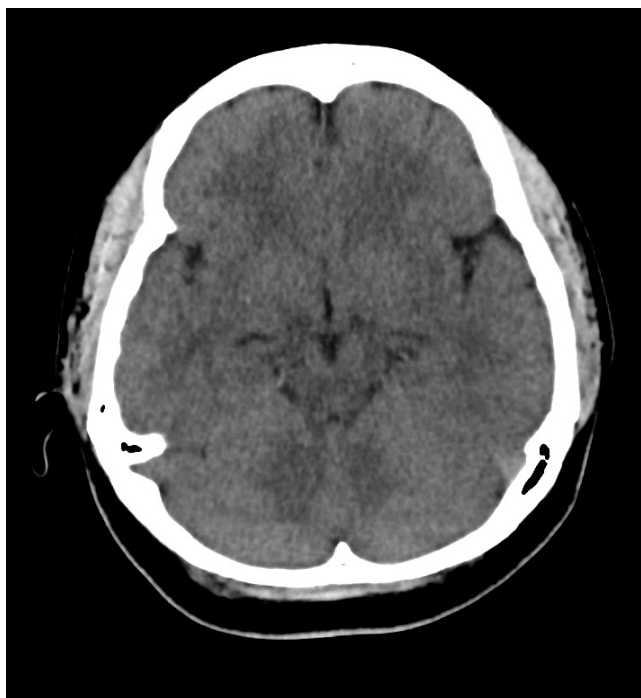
An axial cut CT image day one post surgery showed minimal subdural effusion at left fronto-temporo-parietal region. Midline shift to the right measuring 4.5mm
